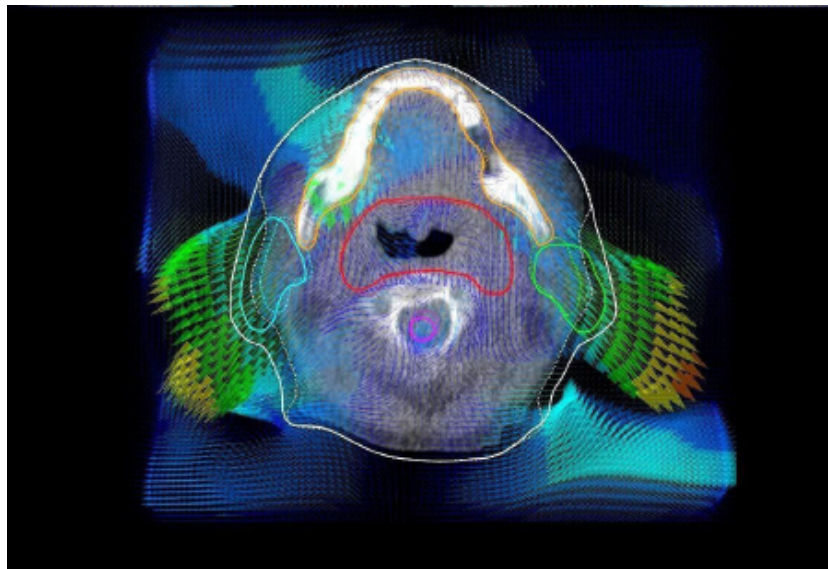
Head and Neck with Plan-CT and 15- day CT are shown rigidly fused. Parotid contours at planning time have been deformed to match 15-day anatomy by using deformable ANACONDA algorithm. ROIs Parotid (left) (green) and Parotid (right) (blue) shown as solid lines on PlanCT and dashed lines on 15 day CT.
